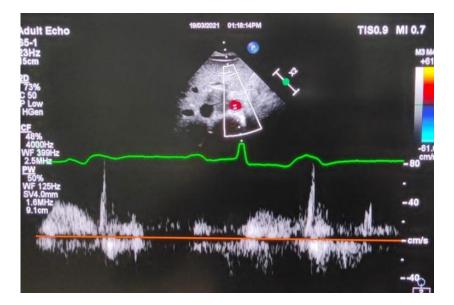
Echocardiography of our patient. Showing aorta on left side and inferior vena cava on right side suggestive of situs solitus
